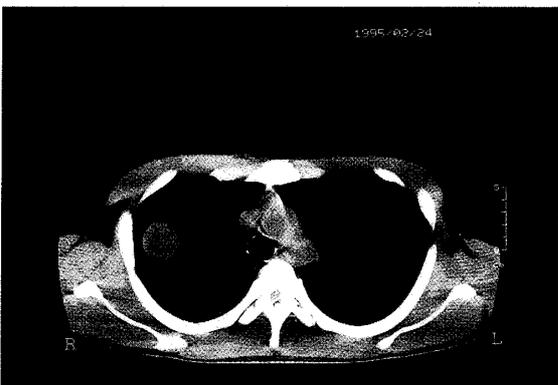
B. Computed tomograph of the chest revealing a mass in the right upper lung. : mediastinal window
